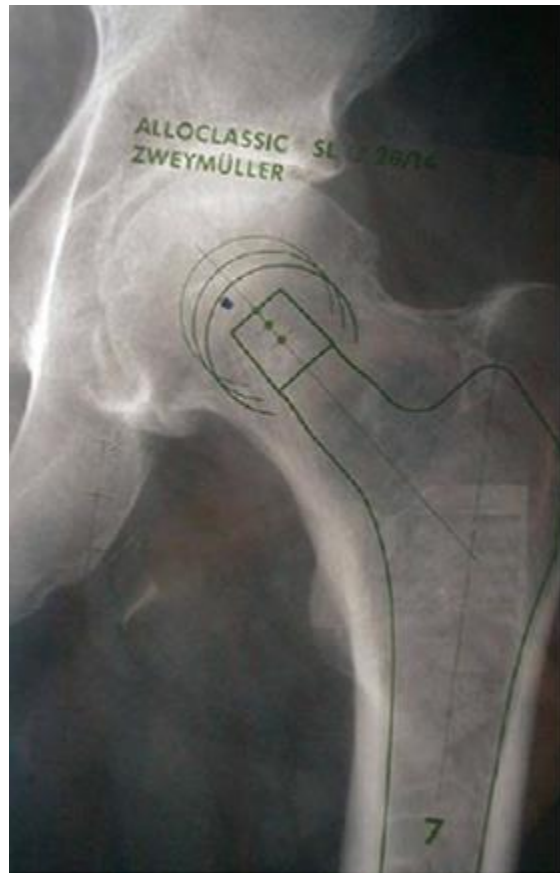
Examples of Upper) 2D radiographic templating (image from Bachour et al. 2010). Lower) 3D biplanar radiographic templating using the EOS system (image from Knafo et al. 2019)
